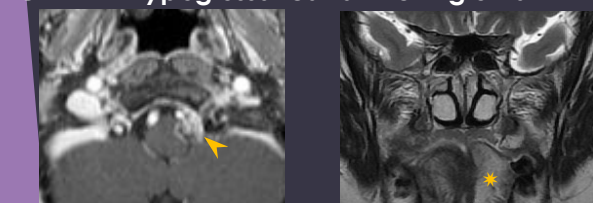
MRI T1 + C shows
